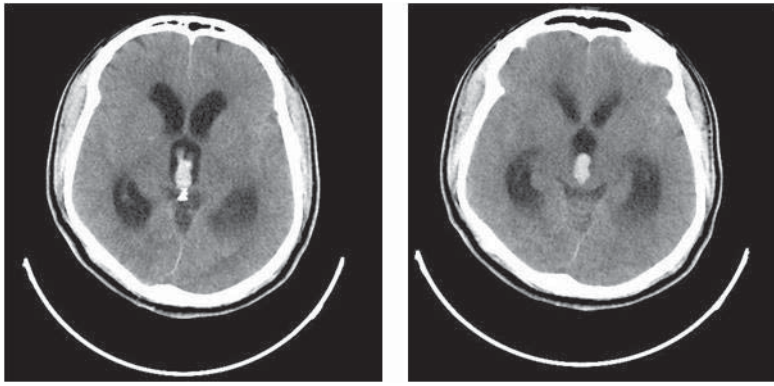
The patient’s CT brain showing IVH in the third ventricle and occipital horns of the lateral ventricles with significantly dilated ventricles
